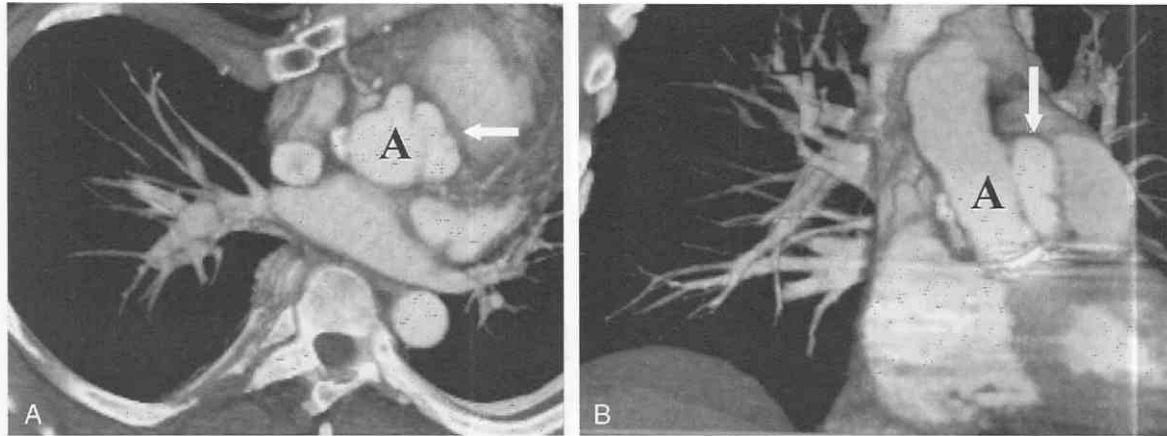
A, Axial CT scan with volumetric rendering shows lobulated soft tissue (arrow) extending from the aortic root (A). B, Coronal volume-rendering image shows pseudoaneurysm (A) arising from the aortic root (arrow).
